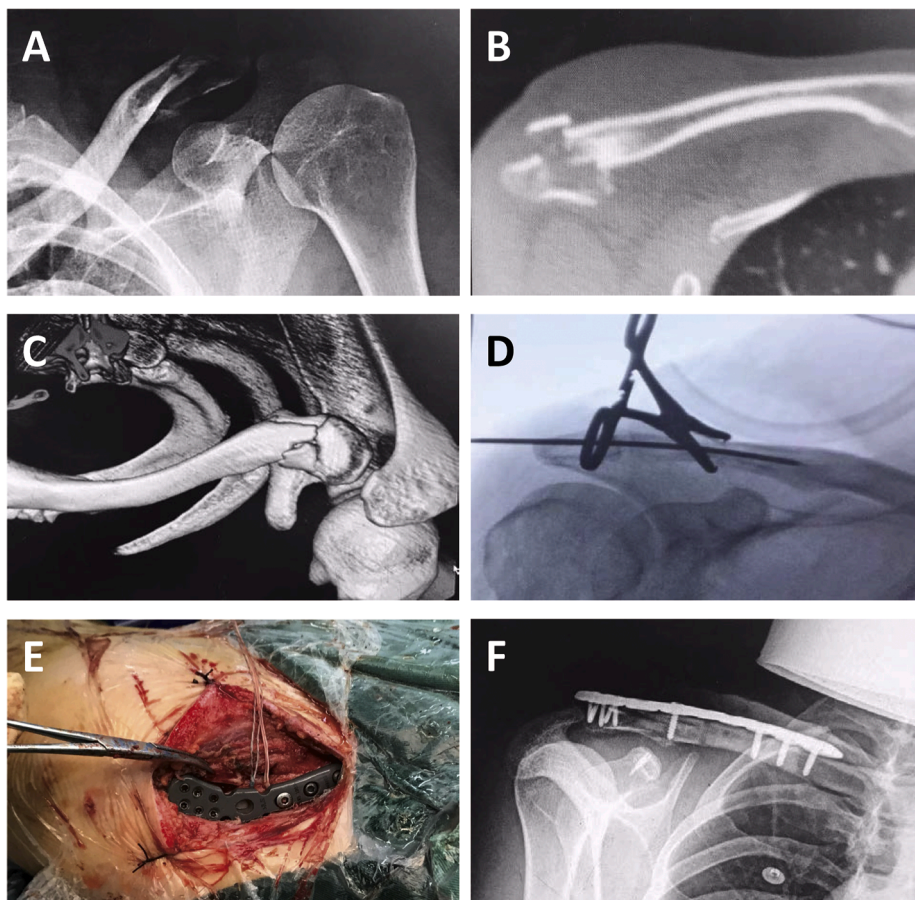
(A) Preoperative X-ray image. (B) Cross-sectional image of CT scan. (C) 3D reconstruction image of CT scan. (D) Temporary fixation using a 2.0 mm Kirschner wire and clamp. (E) Intraoperative image of anatomical locking plate fixation with additional suture anchor fixation (F) Post-operative X-ray image immediately showed good reduction of clavicle fracture.
